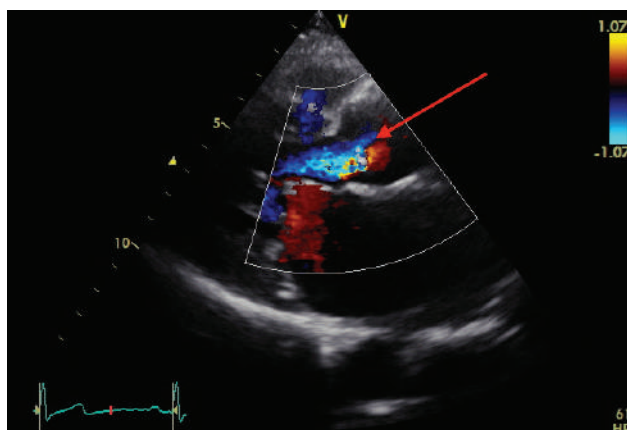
Rheumatic aortic valve with colour Doppler demonstrating regurgitation (red arrow)
